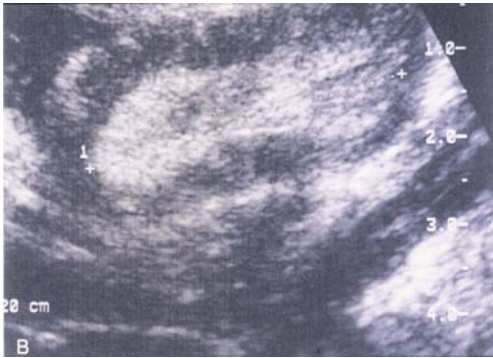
Ultrasound scan showing the "pseudo-kidney" appearance of the intussusception.
